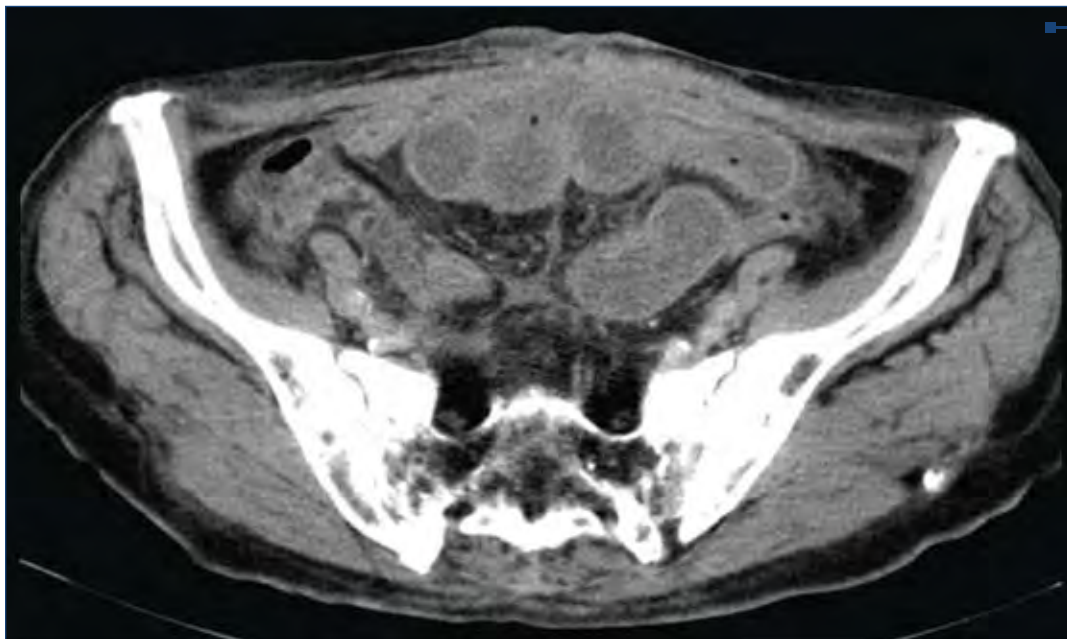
Abdominal computed tomography scan showing agglutinated small intestinal loops
